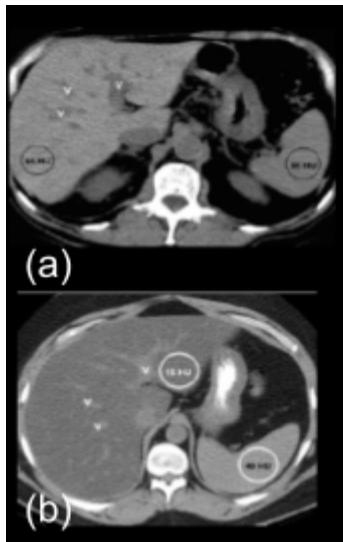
Enhanced CT Scan of Normal(a) and Fatty(b) Liver and Environment
